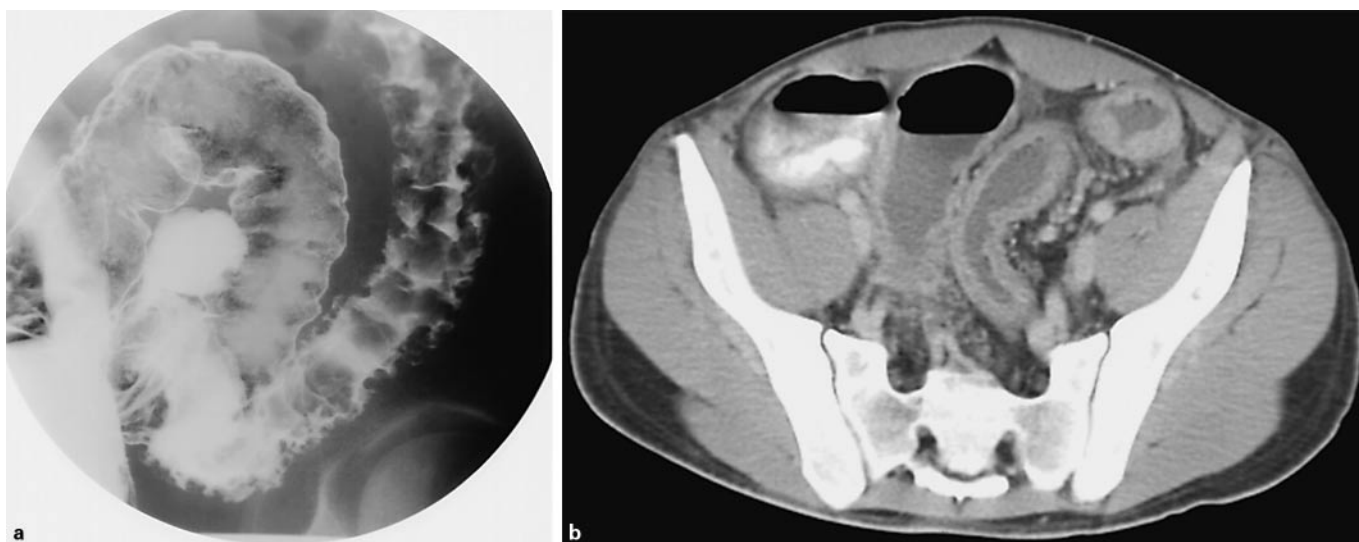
A 23-year-old male with ulcerative colitis. a Barium enema shows multiple collar button ulcers (arrowheads) in the distal sigmoid colon. b Contrast-enhanced CT shows sigmoid colonic wall thickening and prominent vessels (arrowheads) in the sigmoid mesocolon.
